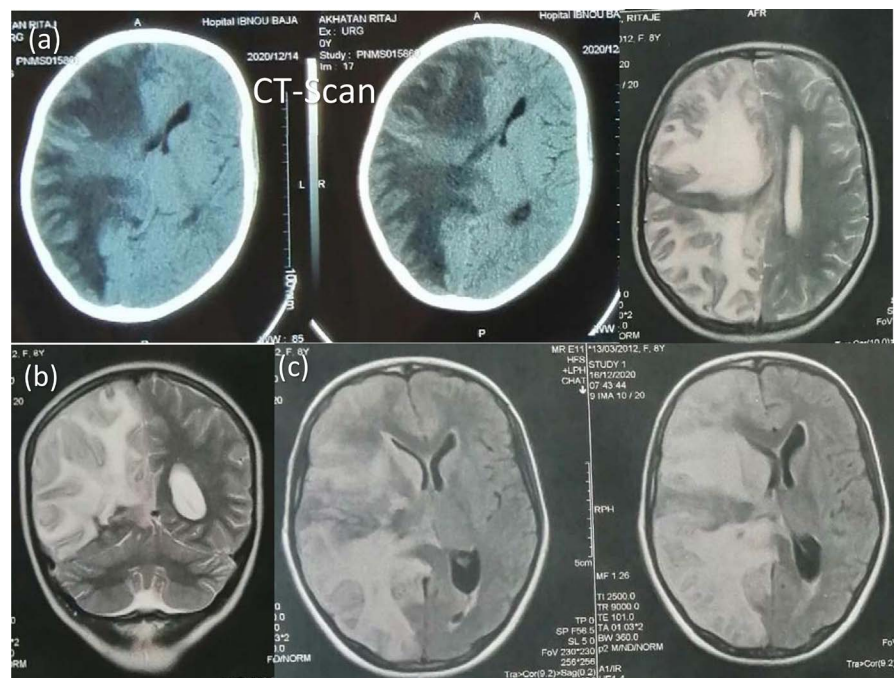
Bain CT-Scan axial section showing right hemisphere lesion with a total hemispheric oedema. (a)-(c): T2 & FLAIR-weighted MRI showing affected right hemisphere that is hyperintense with cortical atrophy.
